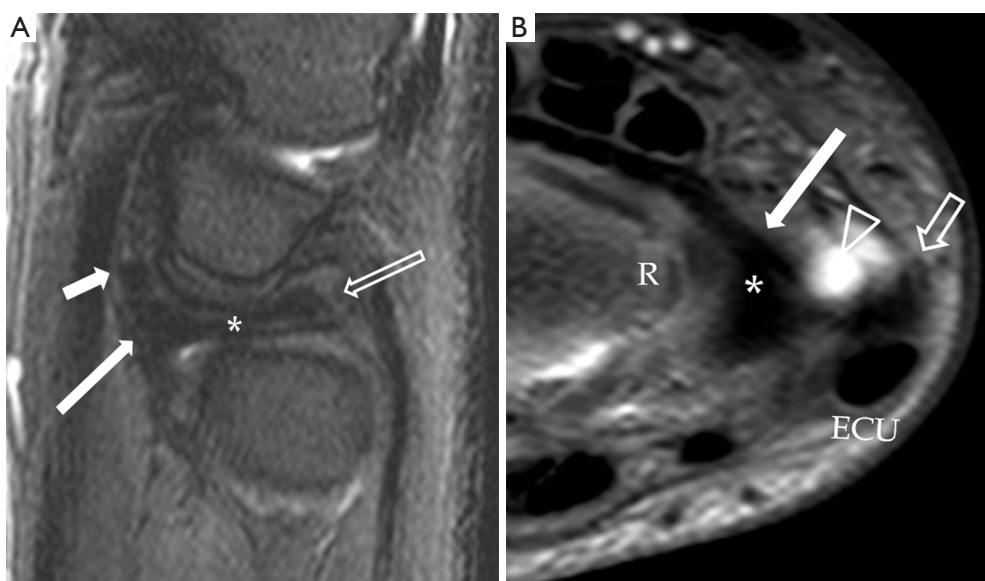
Normal appearance of the TFCC on sagittal T2W fat-suppressed (A) and axial proton-density fat suppressed (B) images. (A) The TFC (asterisk) is concave in appearance on a sagittal view. On the volar side, the TFC is attaching to the volar radioulnar ligament (vRUL) (long solid arrow) and more distally through the ulnotriquetral ligament (short solid arrows). On the dorsal side, the TFC is attaching to the dorsal radioulnar ligament (block block arrow). These structures are not seen as distinct structures on MRI when they are normal; (B) the TFC (asterisk) is barely seen on axial image. On the volar side, the TFC is attaching to a low signal linear structure representing the volar radioulnar ligament (vRUL). On the radial side, it attaches to the distal radial cartilaginous rim (R). On the ulnar side, the attachments are very difficult to be appreciated at this level. However, the location of the distal ulnar styloid process (short block arrow) and the ECU can be appreciated on this image. Fluid within the pre-styloid recess is seen (arrowhead). TFCC, triangular fibrocartilage complex; ECU, extensor carpi ulnaris.
